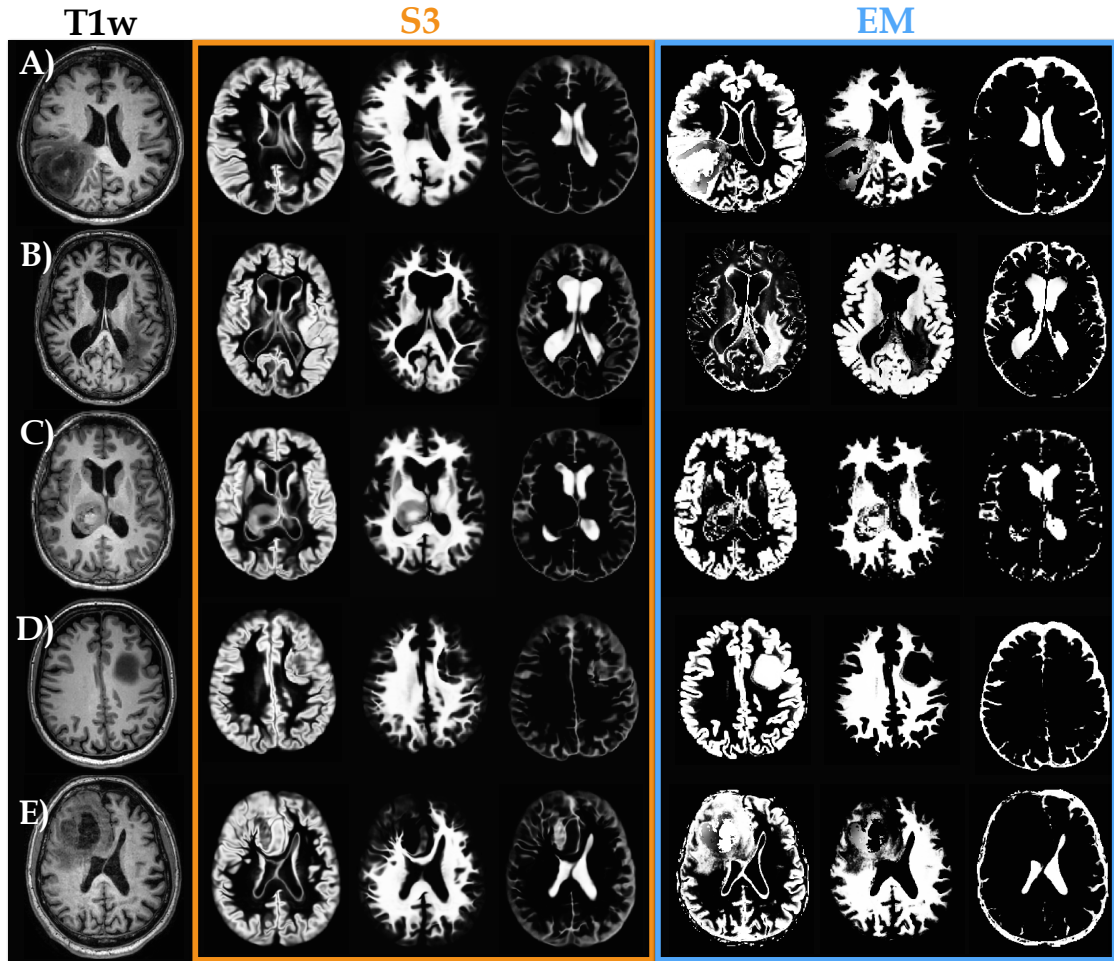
A comparison of brain tissue segmentations computed by S3 (orange box) and EM (blue box) on five scans (A-E) with brain lesions. The input T1w MRI scans for each case (A-E) are shown in the first column. EM method is very sensitive to noise and intensity inhomogeneities, resulting in noisy segmentations. Moreover, EM interprets all brain lesions mainly as gray matter due to their similar intensities in the T1w scan. On the other hand, the S3 segmentations are smooth and less prompt to errors. By mimicking the visible brain anatomies, the S3 segmentations can provide visually reasonable estimates about the tissue below the tumor, in the presence of small tumors, as seen in (A-B). However, all estimates below the tumor must be interpreted with caution as seen in (C-E).
